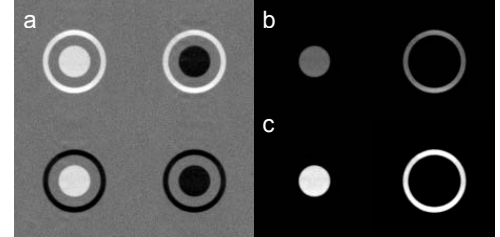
(a) Real part MR images of the ring/circle ROIs acquired with the four polarity combinations. (b,c) Sum/difference images of (a) to eliminate the circle and ring contributions by using (b) only the upper two real images and (c) all four images.
